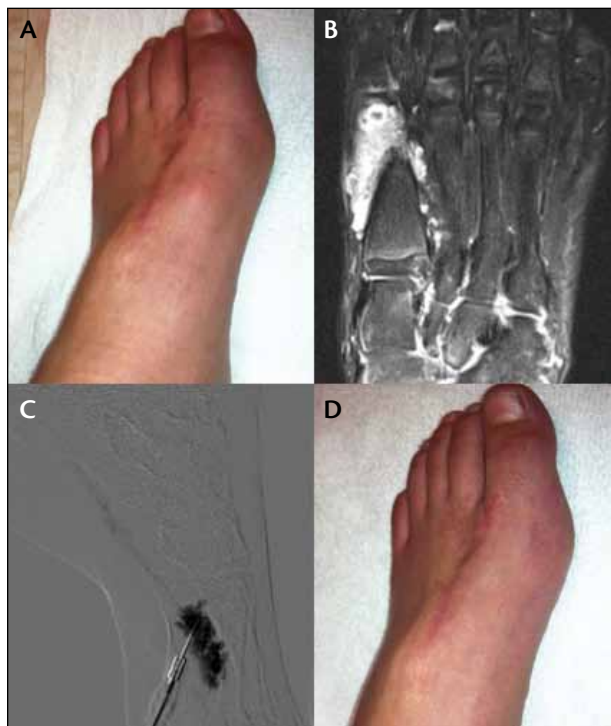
A 12-year-old boy with a history of resection of a left foot venous malformation 5 years ago presented with complaints of severe left foot pain. Clinical examination revealed a compressible bulging structure at the level of the first metatarsal artery (A). MRI T2 weighted images showed recurrence of the venous malformation (B). Venogram that was obtained after the lesion was accessed with direct puncture under ultrasound guidance (C). The lesion was successfully treated with STS. One month after the procedure, the left foot pain had completely resolved, and the initially visualized bulge was no longer seen (D).
